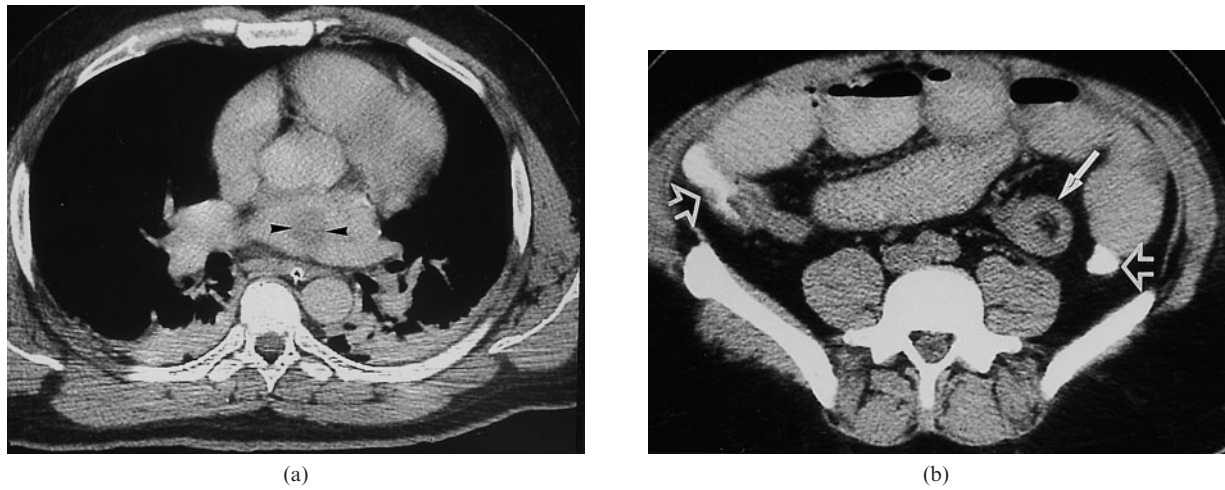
Small bowel intussusception caused by metastatic leiomyosarcoma. A 42-year-old man with malignant leiomyosarcoma of the left atrium, which had been partially resected 3 months earlier. He was admitted with abdominal pain and weight loss. (a) CT of the chest shows a round hypodense lesion in the left atrium (arrow-heads), representing the residual leiomyosarcoma. (b) CT of the abdomen shows a hypodense area in the centre of a small bowel loop in the left abdomen (white arrow), characteristic of invaginated mesenteric fat. The proximal bowel loops are dilated, some with an air–fluid level. Orally administered contrast medium is seen in the colon (open arrows) as evidence of only partial small bowel obstruction.
